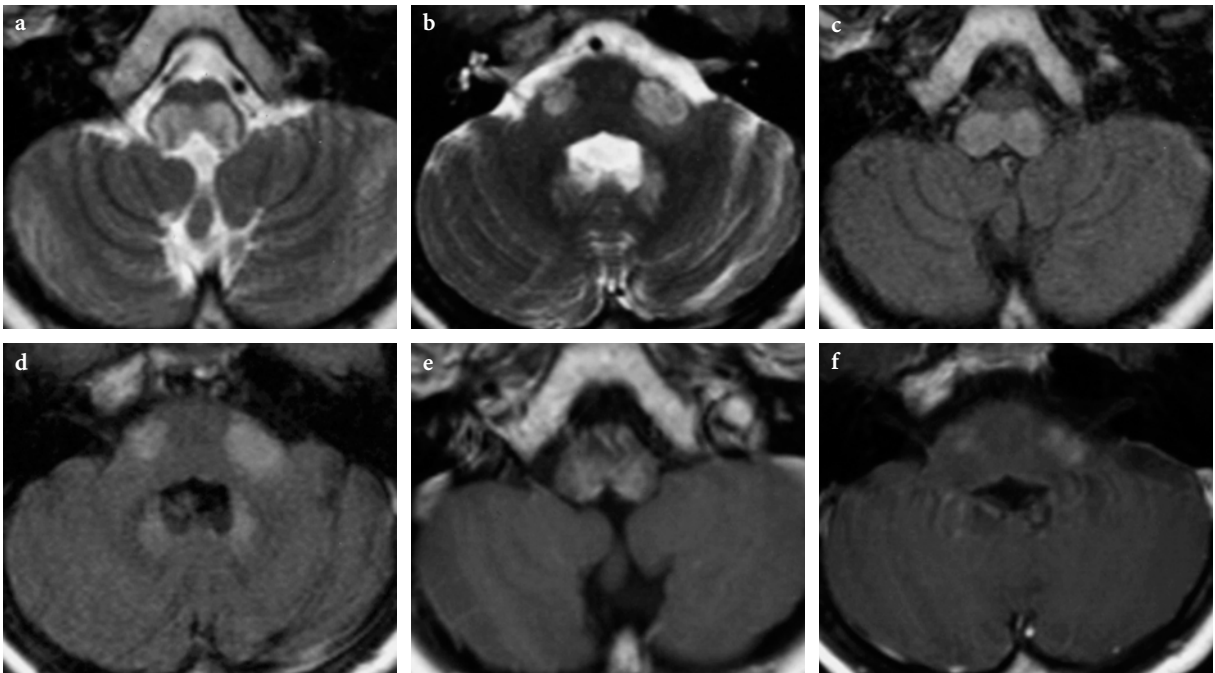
MR imaging findings in a 16-year-old male patient with the juvenile form of Alexander disease (courtesy of Dr. P. Tortori-Donati, Genoa, Italy). a, b Axial T2-weighted images; c, d axial FLAIR images; e, f Gd-enhanced axial T1-weighted images. There are abnormal T2 and FLAIR hyperintensities (a–d) within the posterior medulla, middle cerebellar peduncles, and dentate nuclei, with mild swelling of the affected areas. Notice moderate degree of enhancement after gadolinium administration (e, f). There were neither macrocephaly, nor other lesions, notably in the supratentorial compartment
